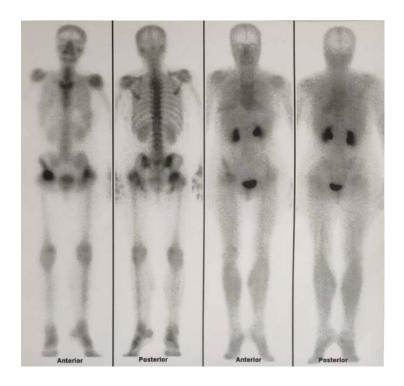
This is an atomic scan image of the patient after treatment or with glucosodiene. An isotopic bone scan using dual-phase bone scintigraphy revealed consistent uptake of the tracer in the previously identified regions, accompanied by slight hyperemic changes during the blood pool phase. The remaining skeletal areas exhibited uniform distribution of the tracer, without any active or cold focal lesions. The publication of this image has been approved by the patient and the owner of this clinical study
